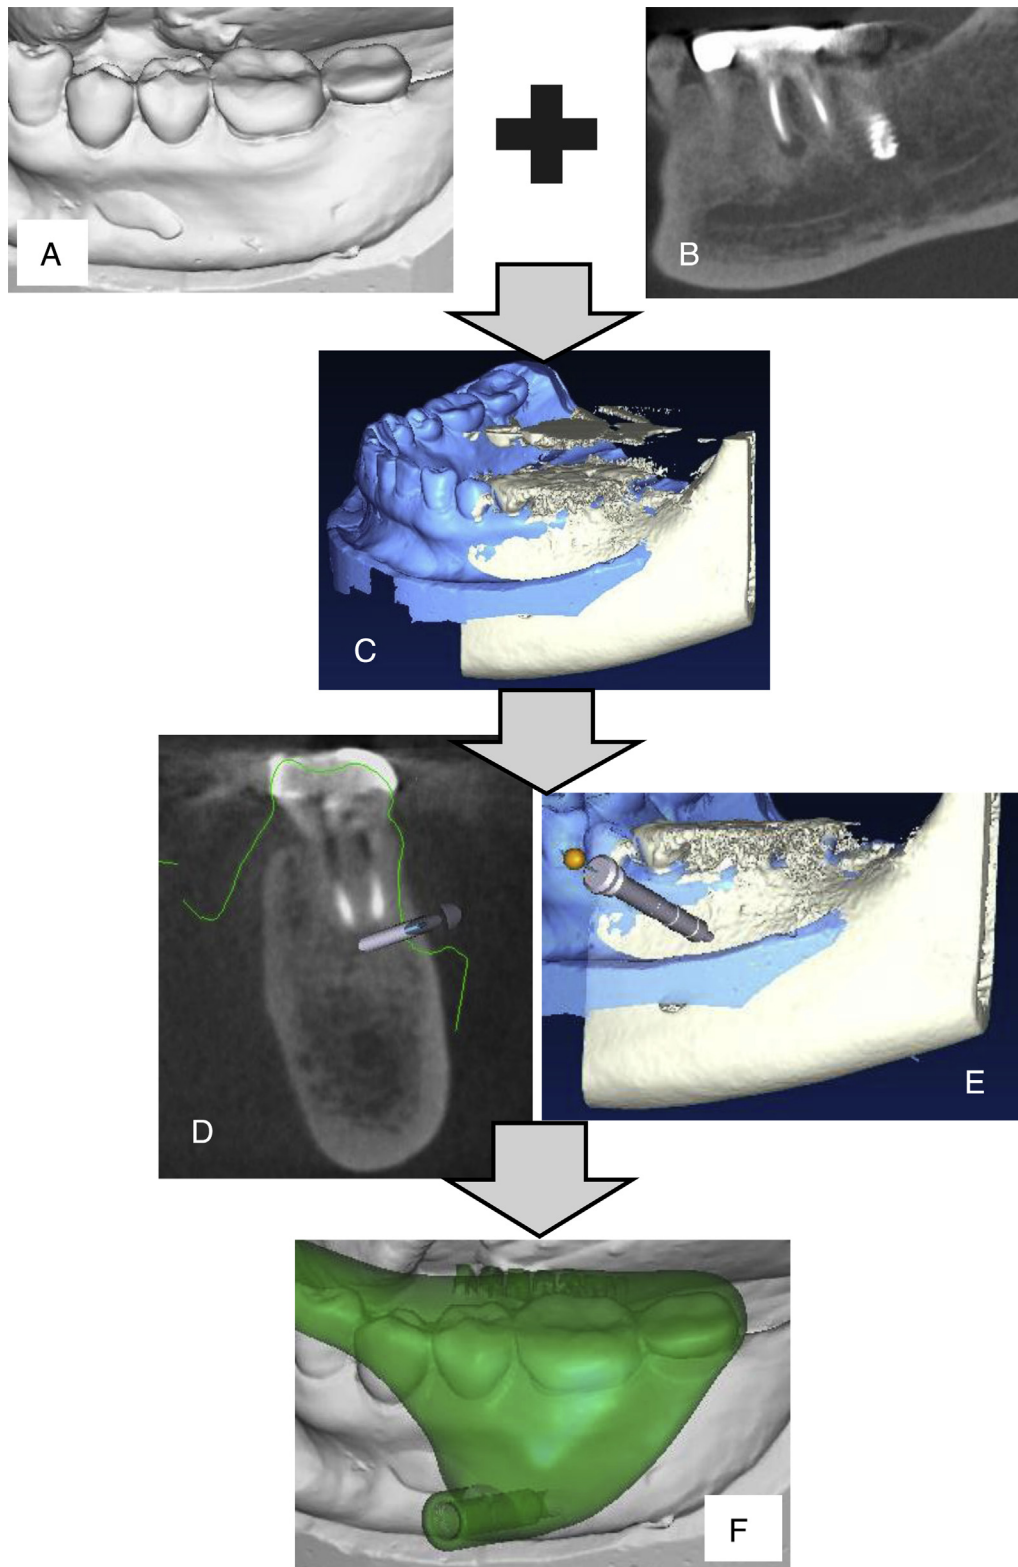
(A) Scanning data of the cast. (B) Tooth CBCT image uploaded into implant surgical planning software. (C) Superimposition of the scanned cast and the CBCT image. (D and E) The anchor pin was placed to target the mesial root apex of tooth 19. (F) The final design of the surgical template.
